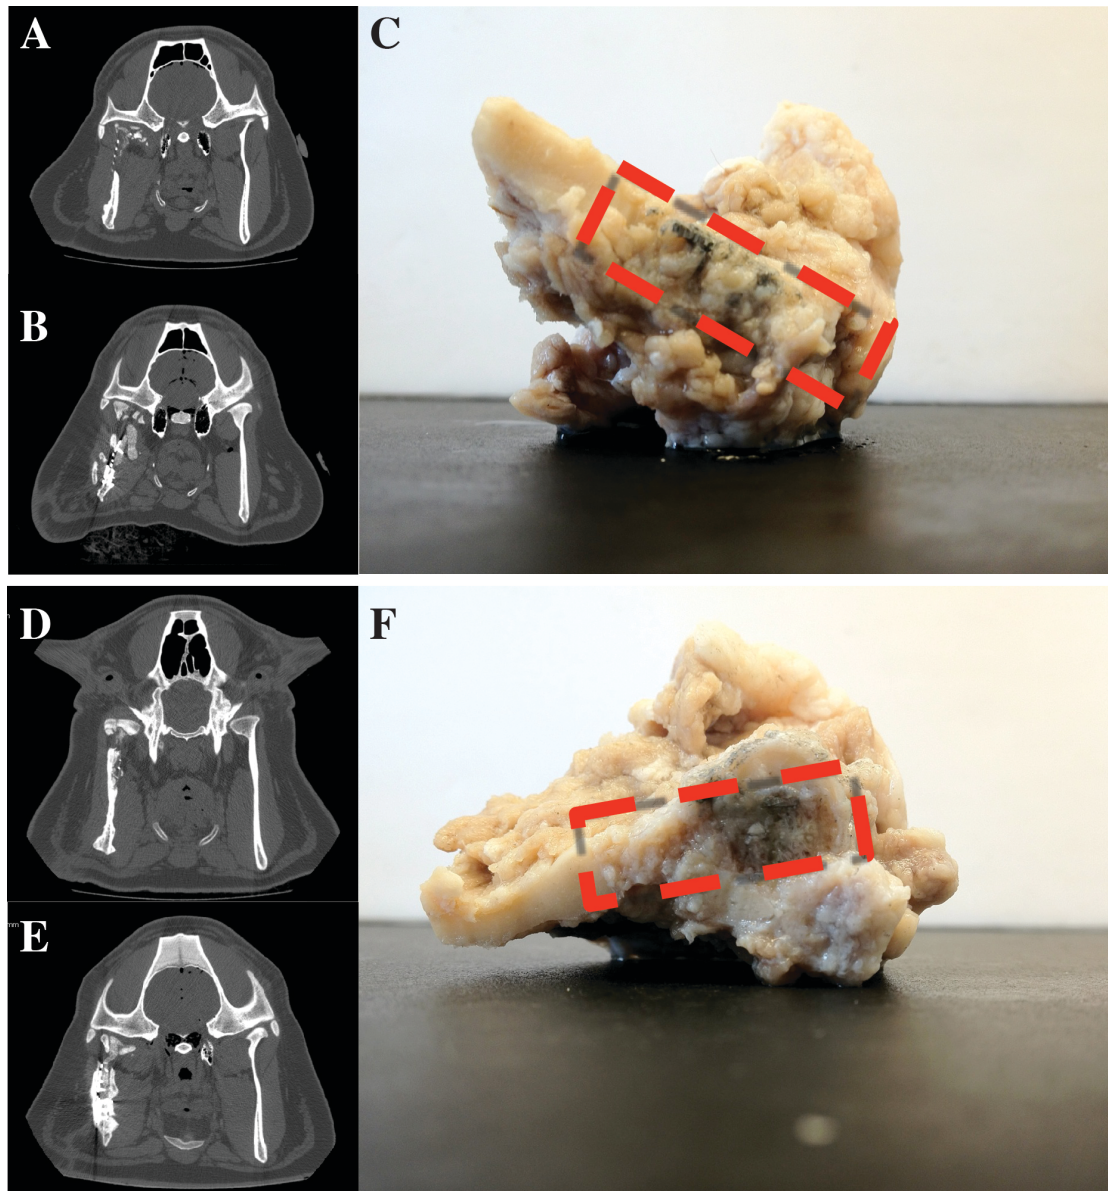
Regeneration of RCU in scaffold implantation (A-C) and engineered autologous graft implantation (D-F). CT images at 3 months showed graft resorption in scaffold implantation (A&B) while the engineered autologous graft implantation showed regeneration of RCU (D&E). Gross section of ramus showed fibrous ingrowth in scaffold implantation (C) at the implanted area (box) as opposed to bone regeneration in engineered autologous graft implantation.
